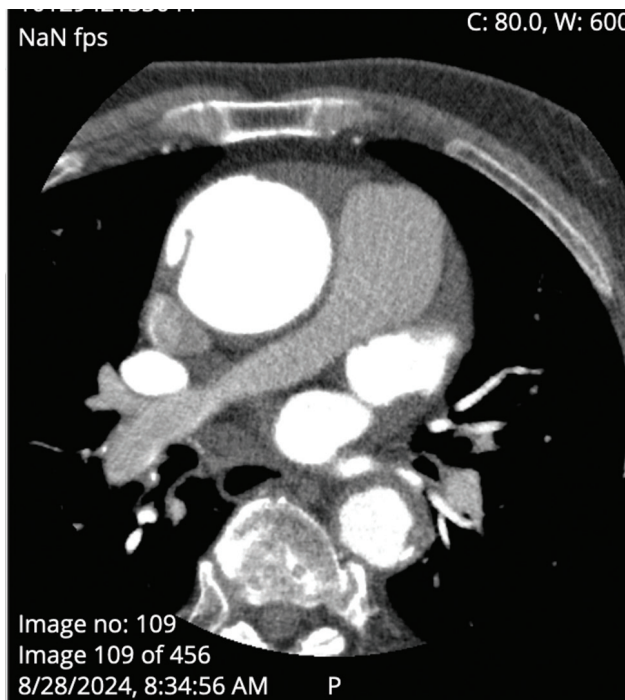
Intimal flap in the ascending aorta on computed tomography coronary angiography.
